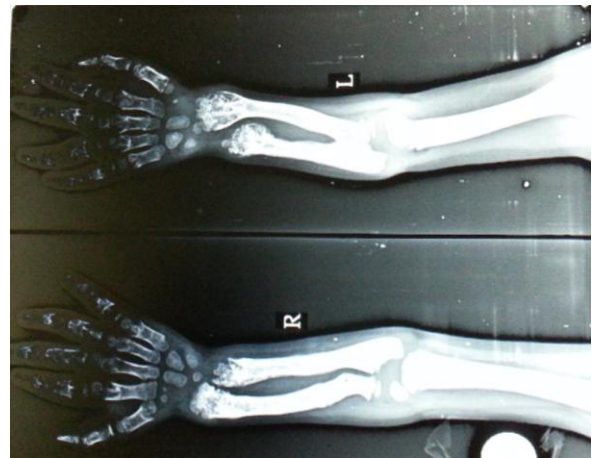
X-ray of forearm and hand
